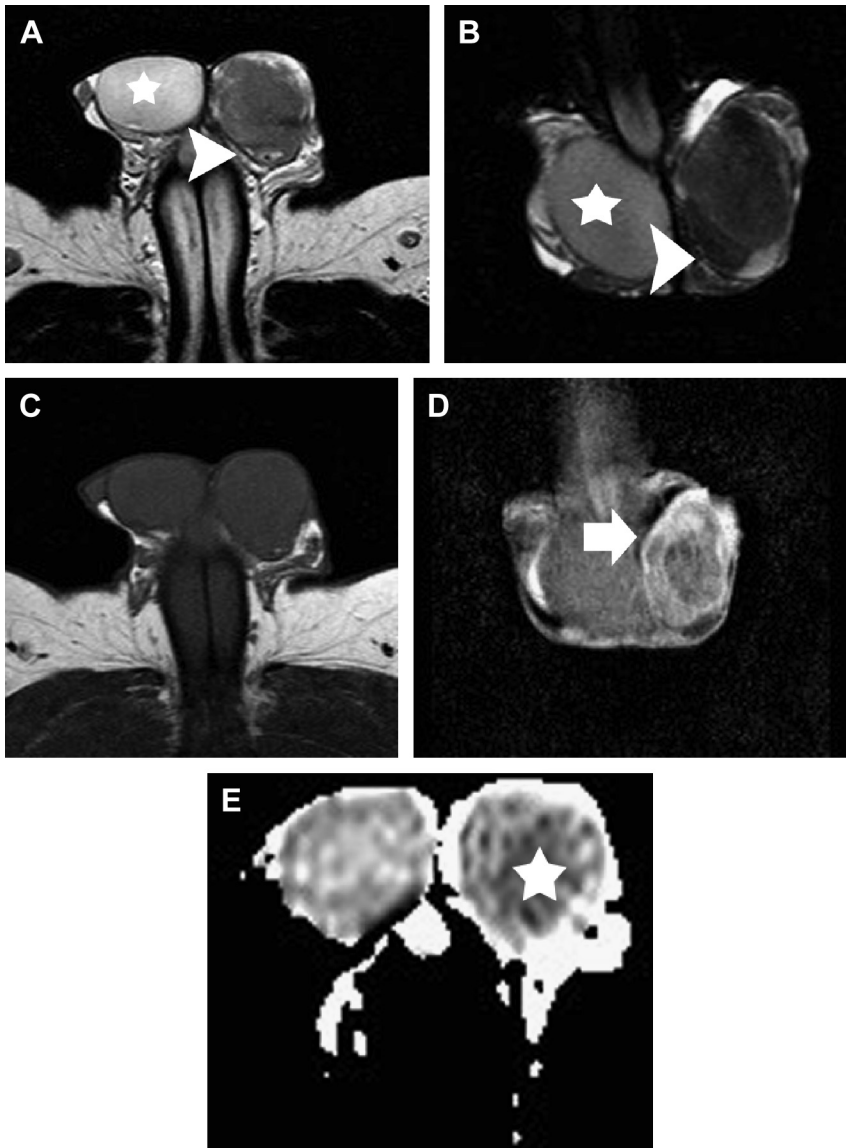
Left testicular seminoma in a 27-year-old man invading the paratesticular space (pT2). (A) Axial and (B) coronal T2-weighted images show left intratesticular tumor extending into the paratesticular space (*arrowhead*). The mass is mainly homogeneous and hypointense when compared with the normal contralateral testis (*asterisk*). (C) Axial T1-weighted image fails to demonstrate the neoplasm. (D) Coronal DCE image depicts inhomogeneous tumor enhancement (*arrow*). (E) Transverse ADC map ($b = 900 \text{ s/mm}^2$) shows restricted tumor diffusion (*asterisk*). The ADC values of the neoplasm are $0.50 \times 10^{-3} \text{ mm}^2/\text{s}^{-1}$, less than that of the normal contralateral testis ($0.98 \times 10^{-3} \text{ mm}^2/\text{s}^{-1}$).
